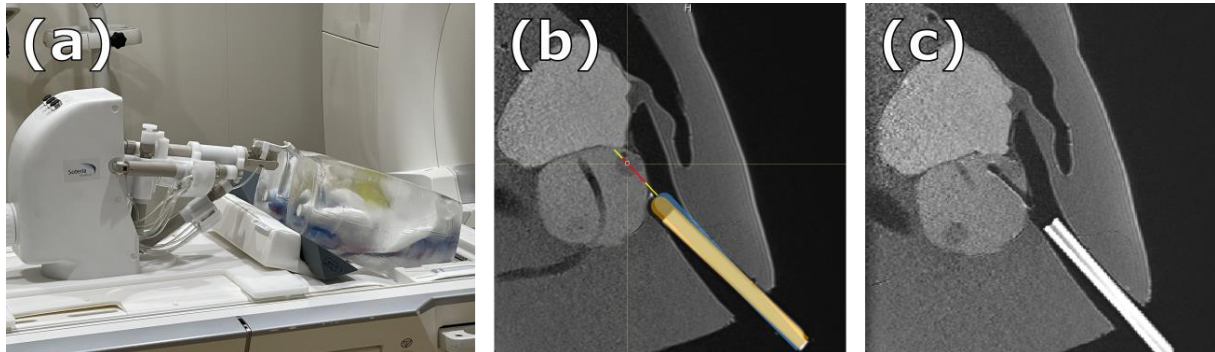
(a) Inbore-MRGB setup. (b) Initial T2w MRI scan, where the current position of the needle probe is shown in yellow. (c) Control T2w MRI scan.
